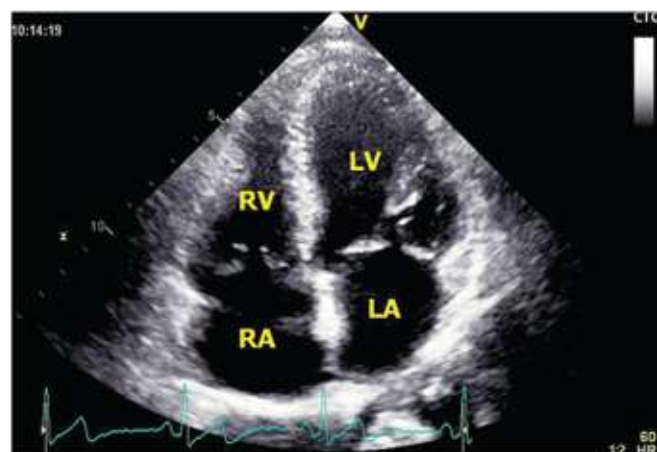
Apical 4-chamber view. LA- left atrium, LV- left ventricle, RA- right atrium, RV- right ventricle
